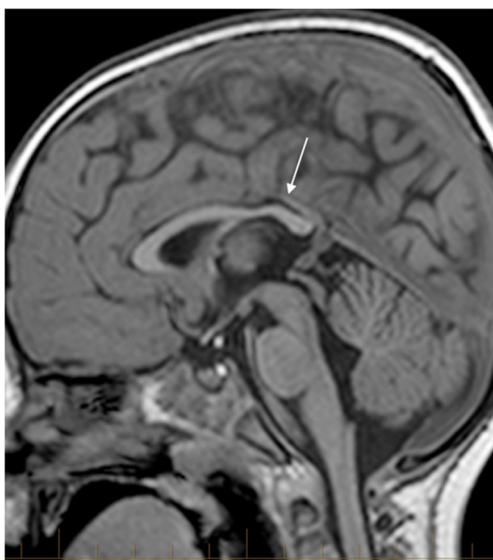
Case 2, a girl age 2 years 3 months. T1-weighted sagittal MR brain image shows dysmorphic splenium of the corpus callosum (*arrow*)
